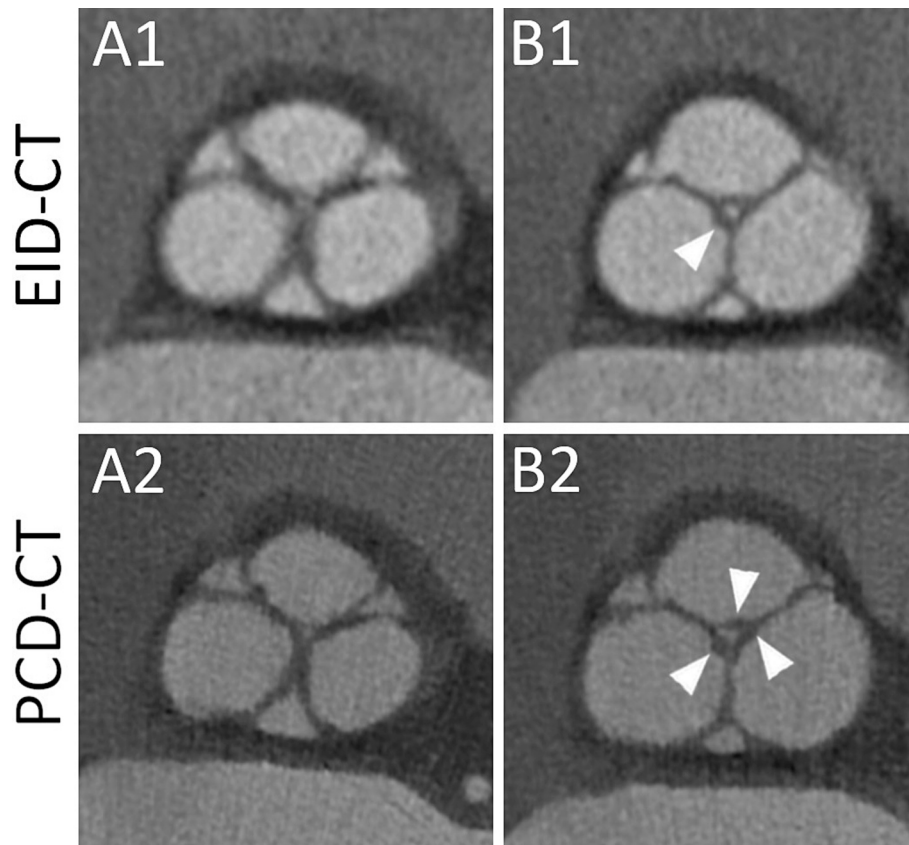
Corresponding images of the aortic valve of the same patient obtained with EID-CT and PCD-CT. Multiplanar reconstructions showing the aortic valve at two different levels (A1 and A2 show the first level; B1 and B2 show the second level) with EID-CT and PCD-CT (first and second line, respectively). The commissures and the edges of the cusps are thickened and, thus, clearly visible with both modalities. However, they appear sharper with PCD-CT in all their parts, including the focal heterogeneities. In addition, while with EID-CT only one nodule of Arantius is visible (arrowhead, B1), with PCD-CT all three of them are visible (arrowheads, B2).
